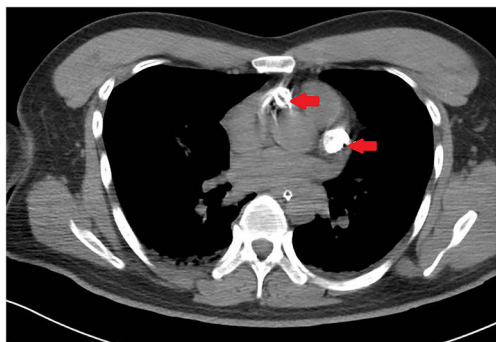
Transverse chest CT image. Red arrows indicate locations of high-density shadows.
